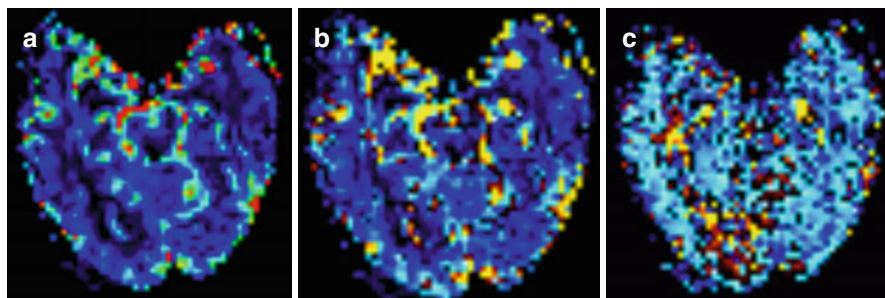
(a–c) The same patient as in Fig. 9.6a. b. Perfusion MR images of the hyperacute stage of infarction in the right PCA territory. CBV map (a) and CBF map (b) show the decrease in perfusion in the cortex and subcortical white matter of the right occipital lobe. The MTT map (Fig. 9.9c) shows the increase in perfusion in the right occipital lobe
